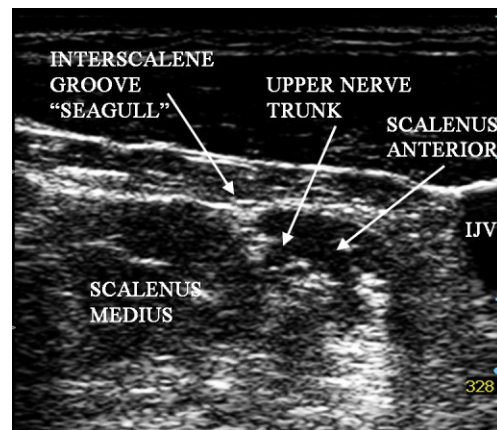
Sonogram of the interscalene groove high in the neck
